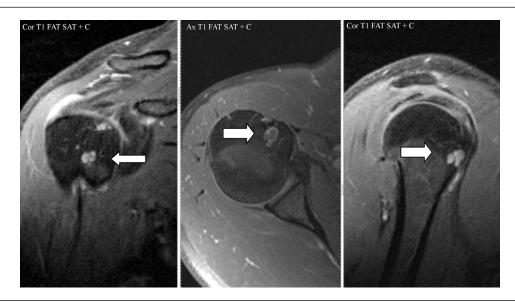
MRI revealing intraosseous ganglion cyst. The white arrows indicates the IOG cyst.
